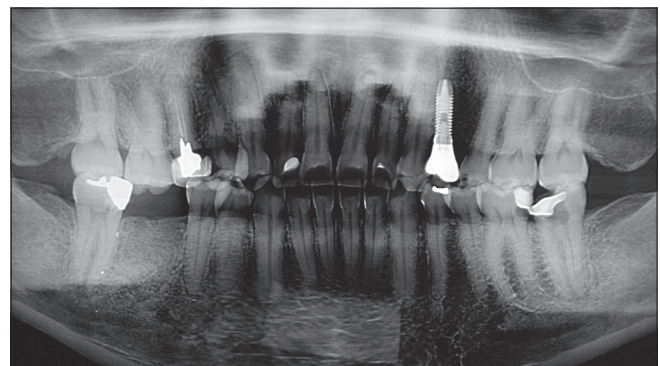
Postmortem panoramic radiograph of the victim dating from 2014
